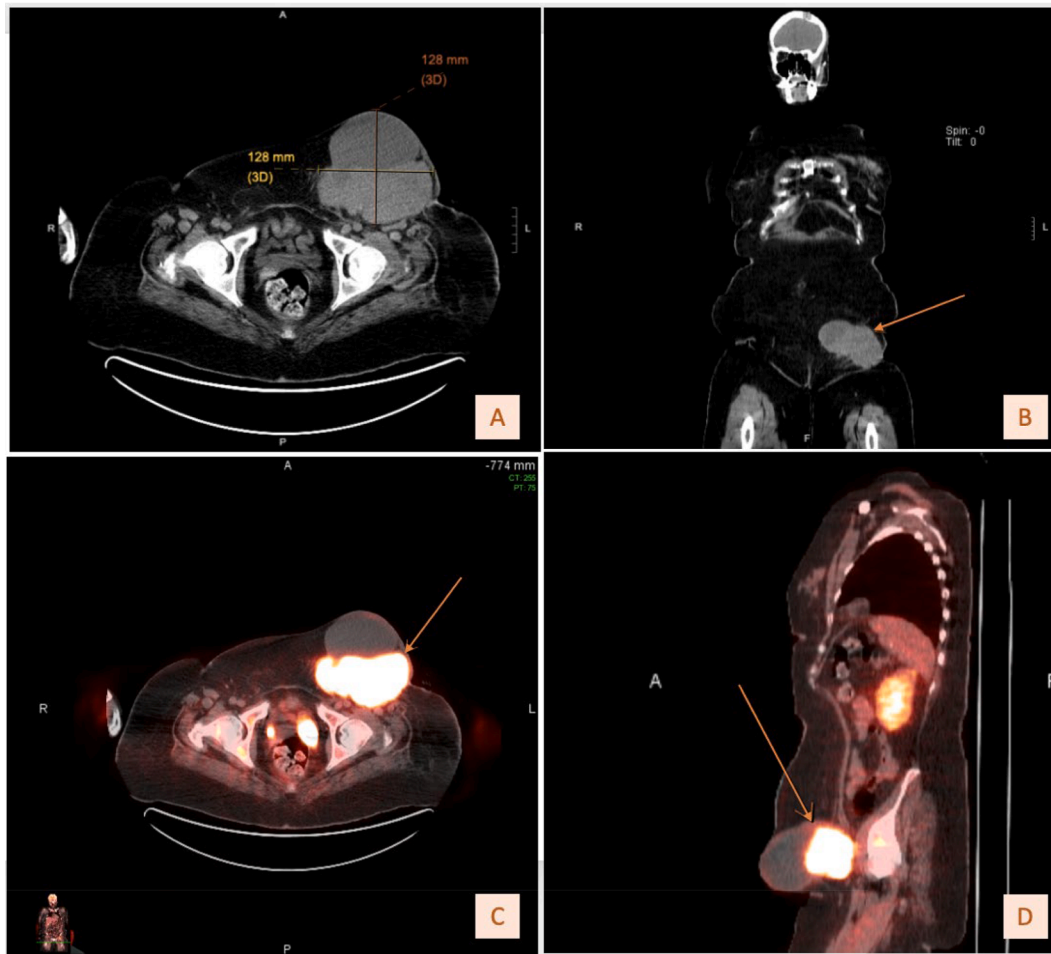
A. Initial axial CT of left inguinal mass measuring 12.8 cm x 12.8 cm. B. Initial coronal CT of left inguinal mass. C. Axial FDG-PET/CT fusion. D. Sagittal FDG-PET/CT fusion.
